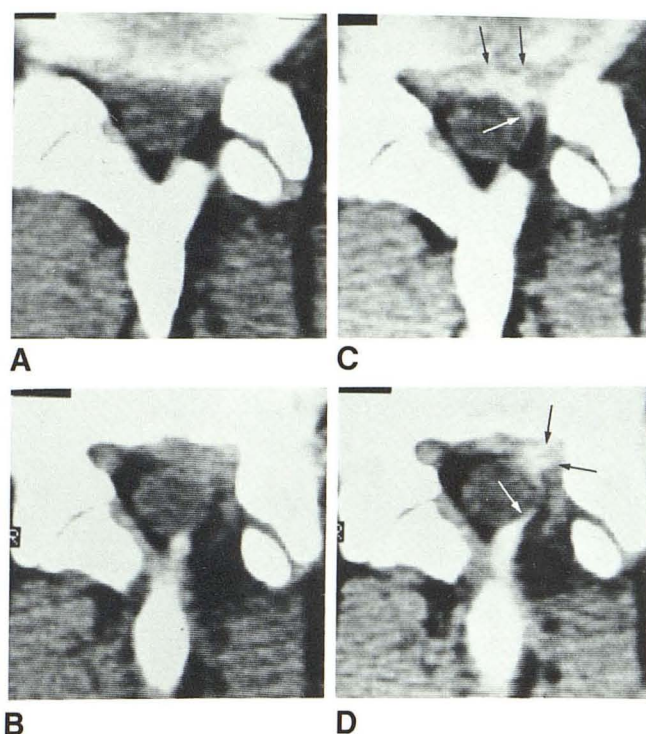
Extension of scar into anulus and nerve root. A and B, 1 year postoperatively. Preenhancement scans at L4–L5 show soft-tissue mass adjacent to anulus and filling left recess. C and D, After enhancement. CT shows enhanced mass with extension of scar tissue (black arrows, C) into irregular anulus and also into irregular left nerve root (black arrows, D). Focal enhancement of dural sac, virtually entirely on side of scar and laminectomy (white arrows).
